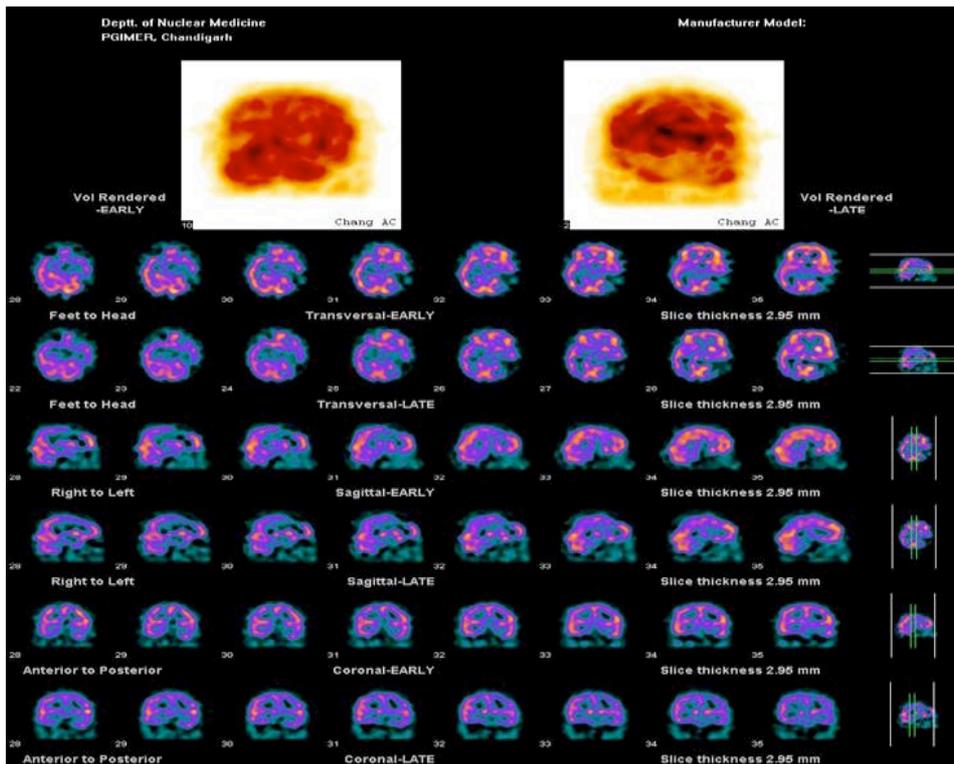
Pre-operative SPECT showing negligible tracer uptake in left parieto occipital cortex and left temporoparietal cortex. Severely reduced tracer uptake in right high frontal cortex. Mildly reduced tracer uptake in left basal ganglia
